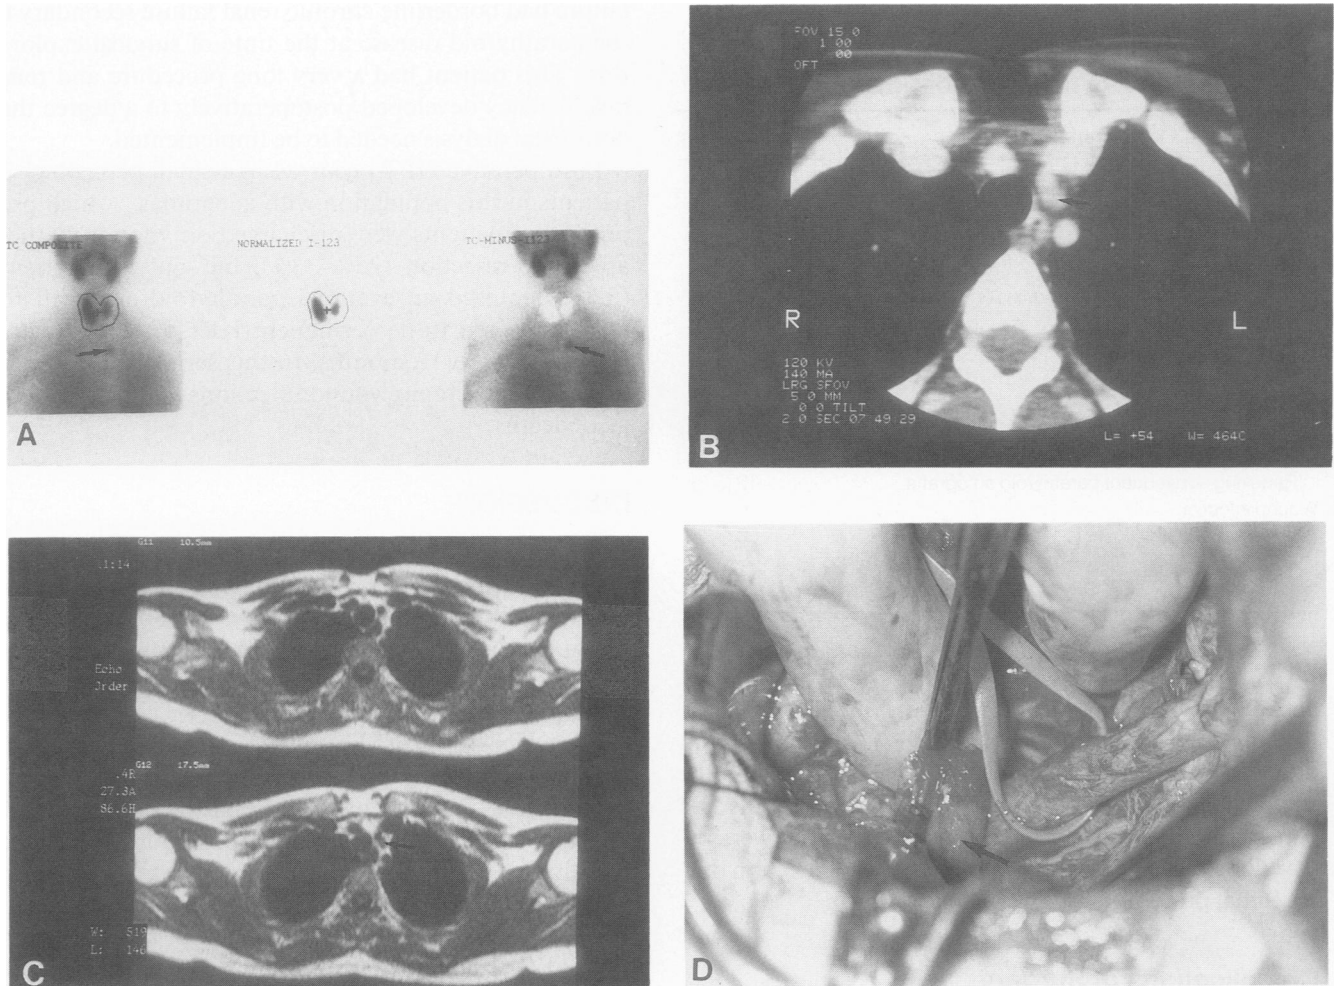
Preoperative imaging studies and an intraoperative photograph from a patient with a carotid sheath lesion posterior to the origin of the left common carotid artery. (A) An iodine sestamibi subtraction study that shows a lesion to the left of midline in the mediastinum, which may be interpreted as being in the thymic gland. (B) A computed tomography scan with contrast, which shows a cut in the upper thorax in which the three great vessels are captured as they arise from the aortic arch. An additional density is noted just posterior to the left common carotid artery (arrow). (C) A T1 weighted magnetic resonance image in the same area, which defines a lesion consistent with the parathyroid more clearly (arrow). (D) An intraoperative photograph taken from the left side of the neck. The common carotid artery is dissected down to the root of the neck and a parathyroid gland (arrow) is being extracted from the posterolateral left common carotid artery.
